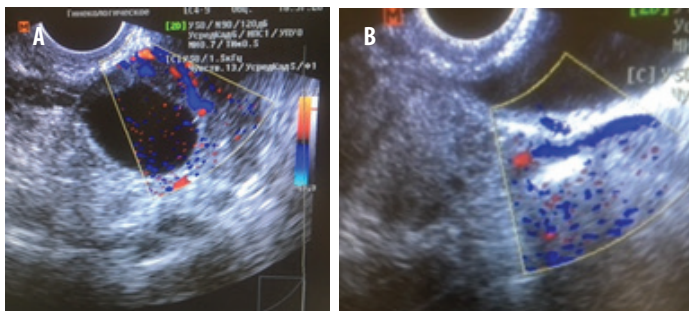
Patient M., group IB (Tazalok™): ultrasound normalization ovarian structures
